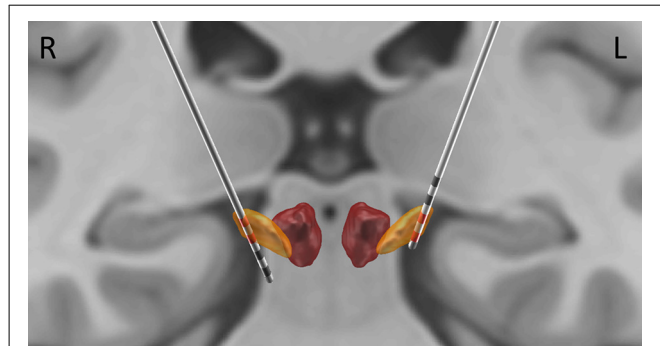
Localization of electrode contacts. The localization was performed based on post-operative CT, coregistered to pre-operative magnetic resonance imaging (MRI). Subthalamic nucleus (STN) and the Red Nucleus are visualized based on DISTAL atlas (Ewert et al., 2018). The contacts used for bipolar derivations reported here (2, 3 on the right; 0, 1 on the left) are highlighted in red.
